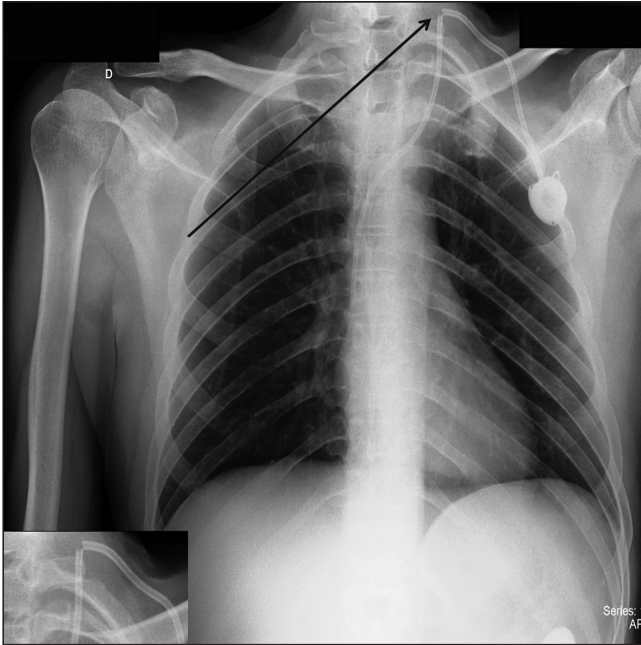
Anteroposterior chest radiograph showing a ruptured catheter in the right upper corner, left side of the patient (black arrow). In the lower left corner of the figure the rupture is highlighted.
